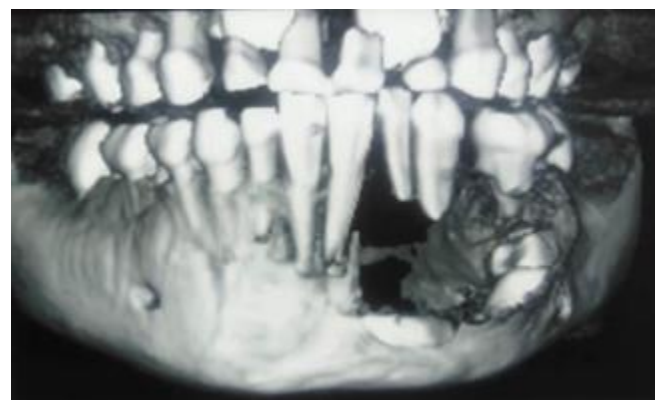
8 months post-operative radiograph
